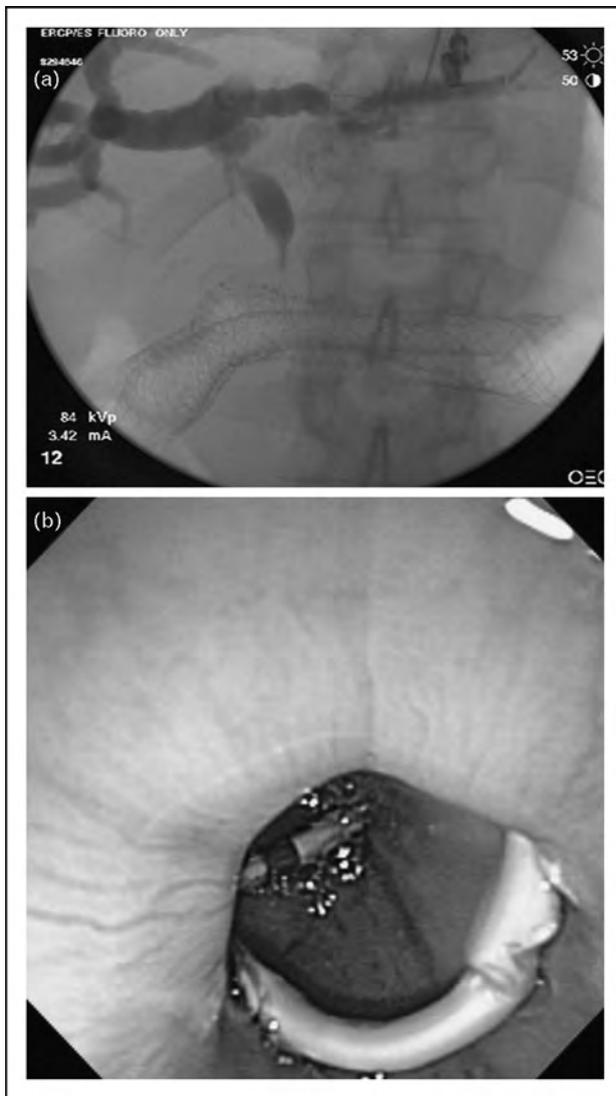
Endoscopic ultrasonography-guided hepatoesophagostomy for transesophageal biliary drainage in a patient with diffuse gastric cancer and gastric outlet obstruction. (a) Transesophageal puncture of left intrahepatic duct was performed using 19-gauge needle and antegrade cholangiogram was obtained. This revealed dilated intrahepatics and severe extrahepatic biliary stricture. (b) Transesophageal plastic stent placement was performed after tract dilation.
